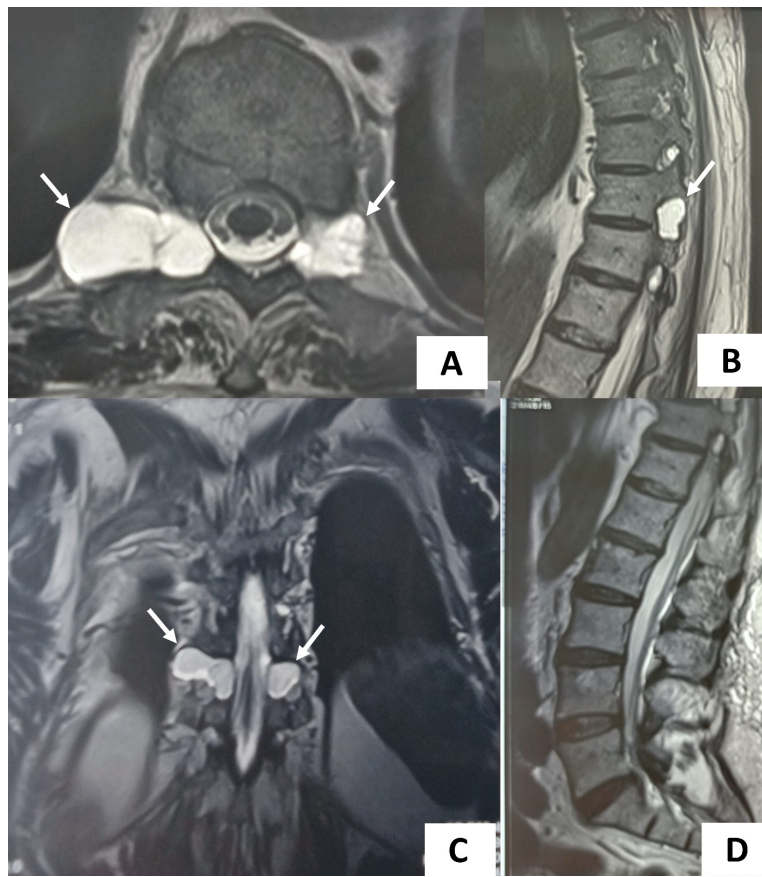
(A): Dorsal spine MRI demonstrated bilateral extradural oval-shaped cystic lesions (arrow) with hyperintensity signal on Fat-suppressed T2-weighted images, corresponding to a CSF-containing cyst. These cysts measured 38x20mm on the right and 20x20mm on the left of T10 on the axial section. (B): MRI sagittal section showing enlargement of neural foramina of T10 (arrow). (C): MRI coronal section did not reveal cyst extension within the spinal canal, nerve fascicle involvement, and solid components within the cysts. (D): Sagittal lumbar spine MRI reveals the absence of the Tarlov Cyst in the lumbosacral region on T2-weighted image.
